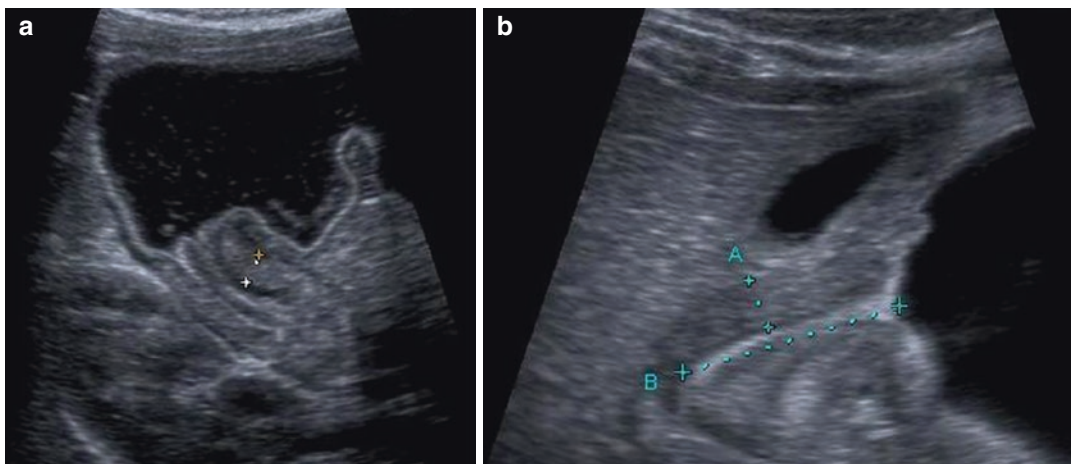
Ultrasound images of hypertrophic pyloric stenosis measuring the width (a) and both diameters (b)
